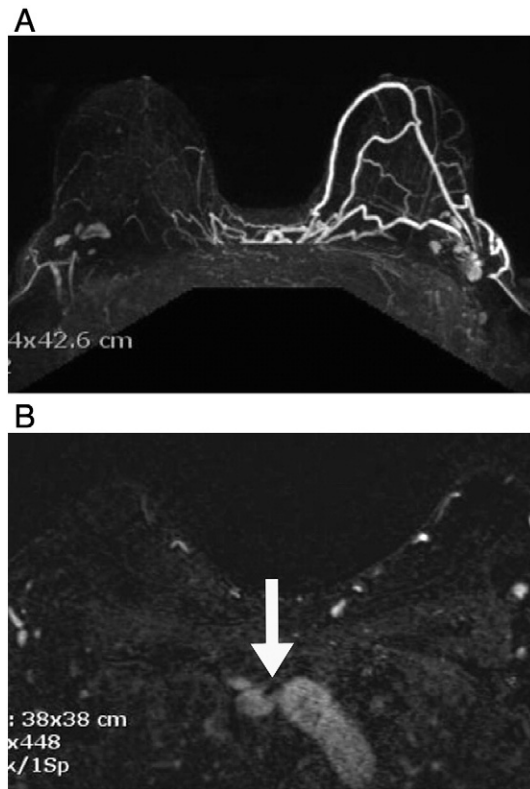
Brachiocephalic vein thrombosis. (1a) Subtraction maximum intensity projection image demonstrates multiple collateral vessels throughout the left breast, new since the prior study that was obtained at the time of diagnosis. (1b) Subtraction T1 fat-saturated postcontrast image demonstrates signal void from the catheter (arrow) entering the superior vena cava. There is no contrast opacification of the left brachiocephalic vein (bcv). Nonopacification of the left bcv and diffuse new collateralization of the left breast raise concern for bcv thrombosis, which was confirmed on ultrasound.
